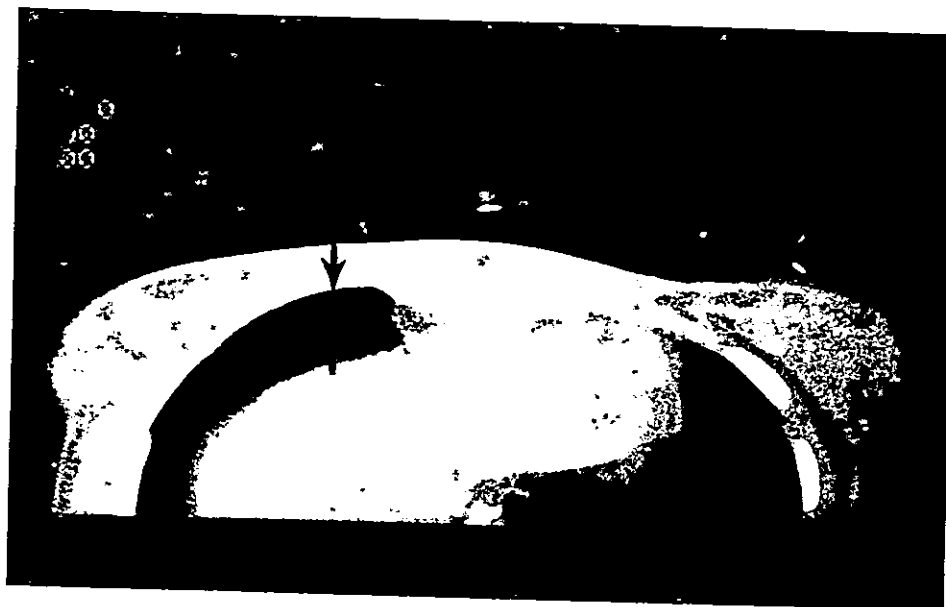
CT of pneumothorax. Close-up axial CT section obtained through lung base as part of abdominal CT study after blunt trauma revealed a small anterior pneumothorax on right anteriorly (arrows). The pneumothorax was not demonstrated on admission chest radiographs.
